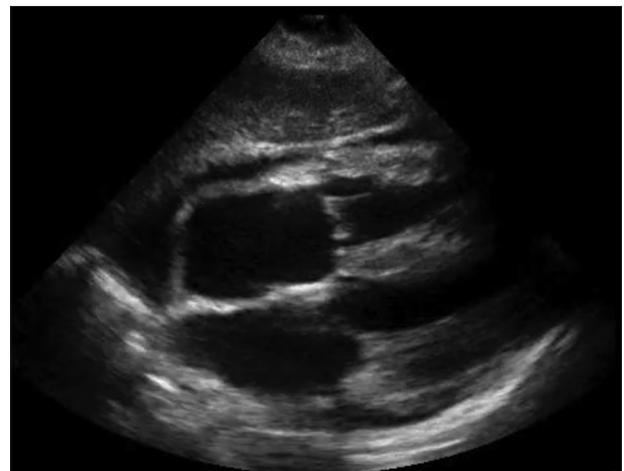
Apical four-chamber view showing features of cardiac tamponade
